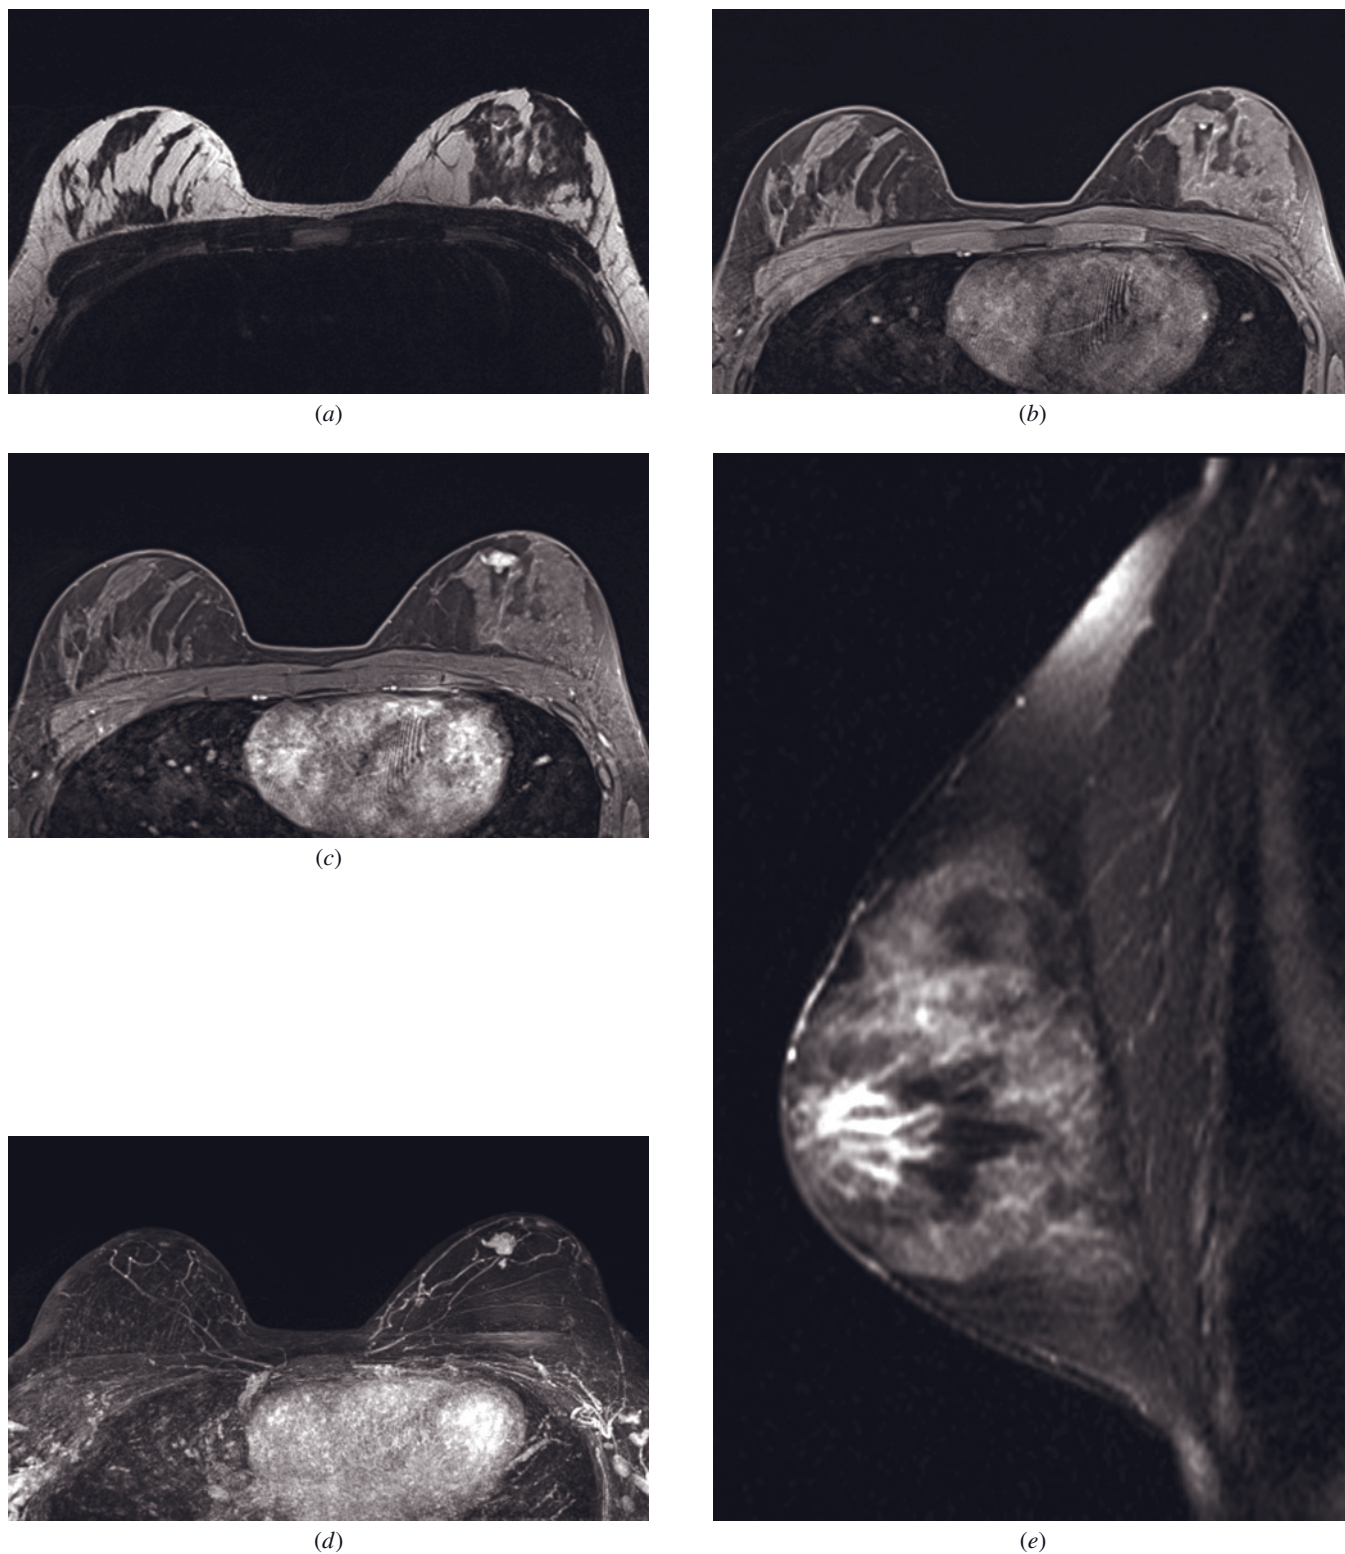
Papilloma. Axial T2-weighted (*a*) and axial GRE (*b*) images show a well-circumscribed, oval, isointense mass located just below the subareolar region. On postcontrast GRE (*c*) and MIP (*d*) images it is seen as a strongly enhancing, slightly heterogeneous, lobulated mass. Papillomas are usually accompanied by dilated ducts as shown on the sagittal fat-saturated T2-weighted image (*e*). An ROI analysis of the dynamic images reveals a type III (washout) curve (*f*) that increases in signal intensity by 127%
